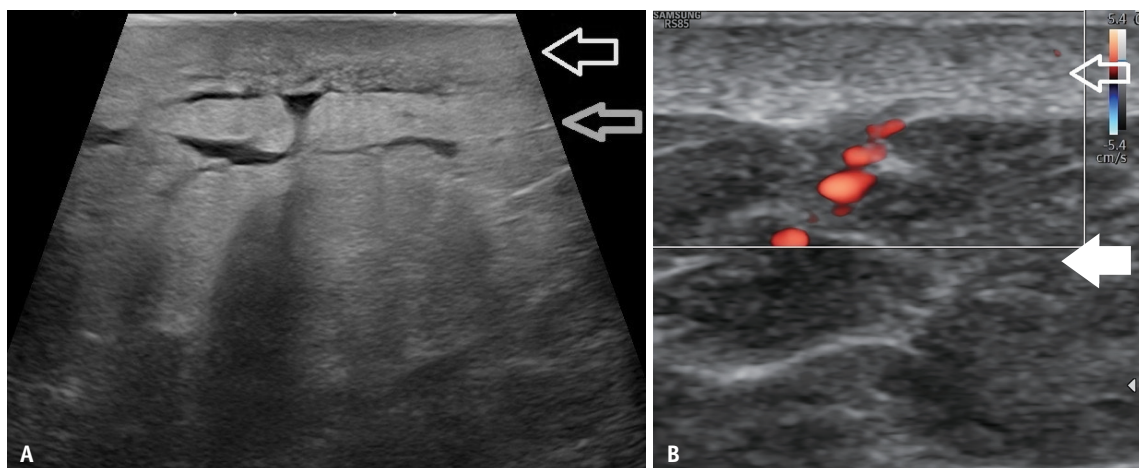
Post-radiation therapy acute radiodermatitis. Ultrasound scan at 22 MHz. A: The dermis is thick and hypoechoic (white arrow). The subcutaneous fat lobes below are hyperechoic, with septal fluid accumulation (gray arrow). B: Normal skin appearance for comparison (power-Doppler scan), with the echoic dermis (white open arrow) and the hypoechoic subcutis (white arrow). The dermal-hypodermal boundary is well-defined, and flow signals are limited to the subcutaneous layer.
